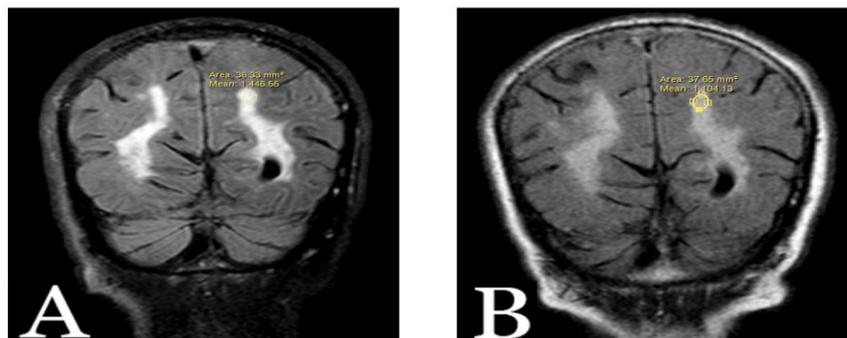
66 year old male hypertensive and diabetic patient presented with blurred vision. A and B are T2 FLAIR coronal images. A: show the intensity of the lesion in 3 tesla MRI. B: show the intensity of the lesion in 1.5 tesla MRI.
